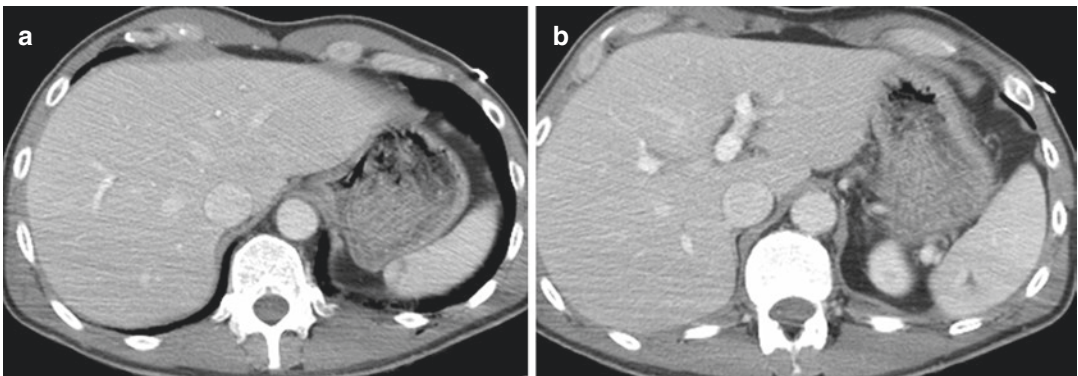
(a, b) First contrast-enhanced CT on arrival at emergency room. At the level of the upper pole and the middle of the spleen there are some ipodense areas, diagnosed as parenchymal lacerations; currently, no evidence of subcapsular or perisplenic hematoma is seen
